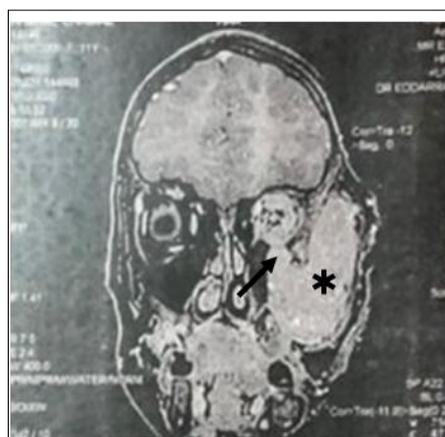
Facial MRI in frontal section showing a voluminous lesion process centred on the left infra-temporal fossa extended to the left orbital fat in T1 iso signal.
